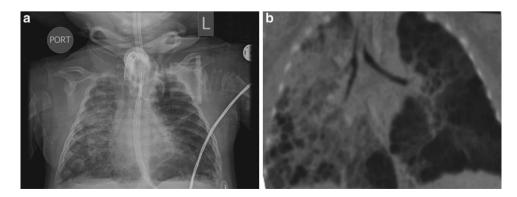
Infant with severe BPD. (a) Plain chest radiograph. (b) CT angiogram showing severe cystic changes (Courtesy of, (CHOP), Chronic Lung Disease program
